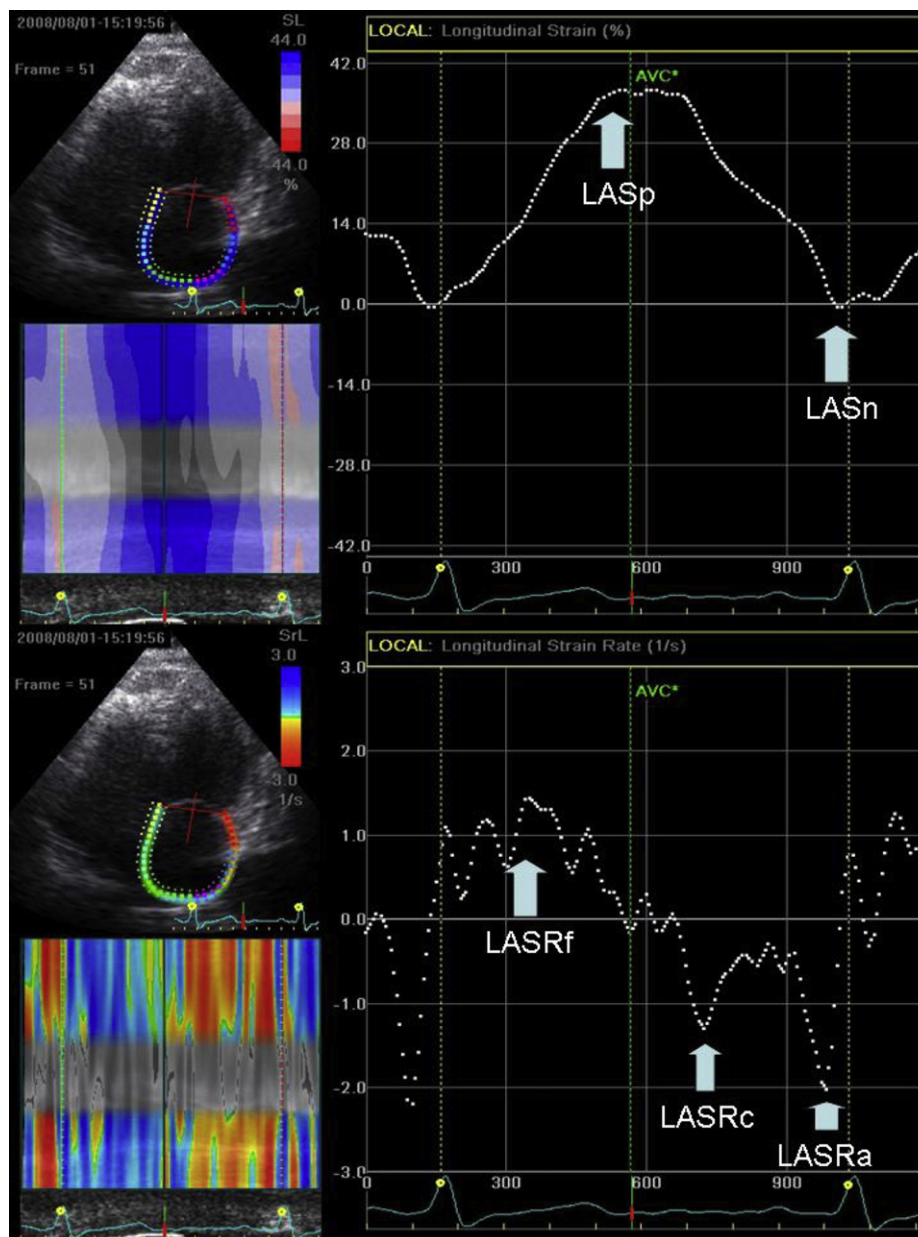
The figure shows strain (upper panel) and strain rate (lower panel) curves of the left atrium (LA) by using speckle tracking echocardiography (STE). LASp represents left atrial peak positive strain, and LASn represents left atrial peak negative strain after P-wave. LASRf represents left atrial peak positive strain rate in left atrial filling, LASRc represents left atrial peak negative strain rate in left ventricular early filling, and LASRa represents left atrial peak negative strain rate during atrial contraction.
